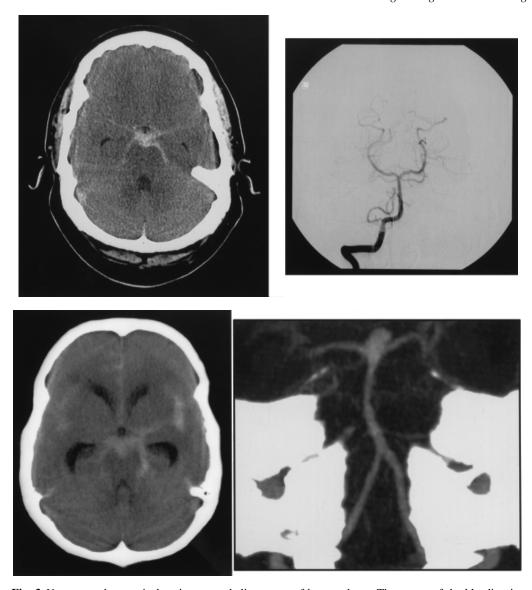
Upper panels*: a typical perimesencephalic pattern of haemorrhage. The centre of the bleeding is in the interpeduncular cistern; the haemorrhage extends into both ambient cisterns and the basal parts of the sylvian fissure, but not into the lateral parts of the sylvian fissures or the anterior interhemispheric fissure. The angiogram shows no basilar aneurysm, nor a vertebral artery aneurysm on the right. Angiography of the left vertebral artery was also normal (not shown). *Lower panels*: a patient with the centre of the haemorrhage in the interpeduncular cistern, but with extension into the lateral part of the sylvian fissures and into the anterior interhemispheric fissure. CT angiography shows a basilar tip aneurysm.
